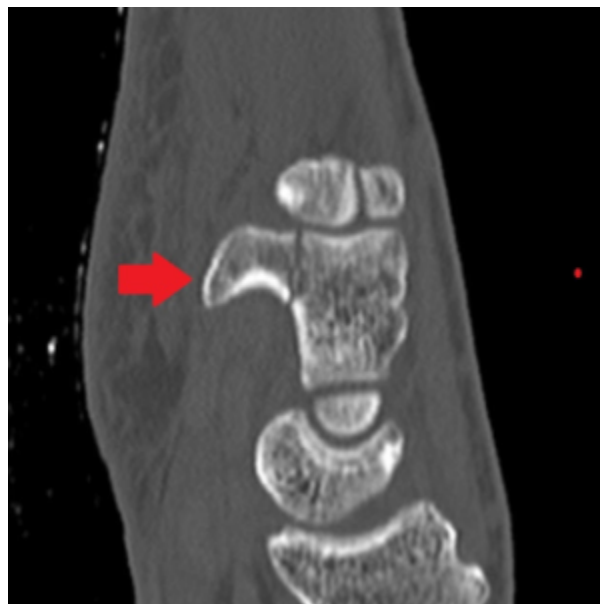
Hamate fracture as seen on CT (credit Radiopaedia.org
